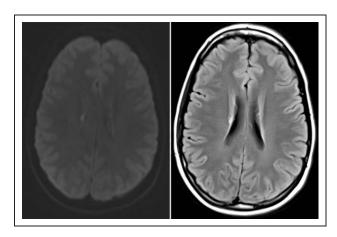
MRI brain, DWI left and axial flair right. A small focus of low diffusivity on DWI and nonenhancing T2 prolongation on axial flair is seen within the right caudate nucleus adjacent to the right lateral ventricle body.
